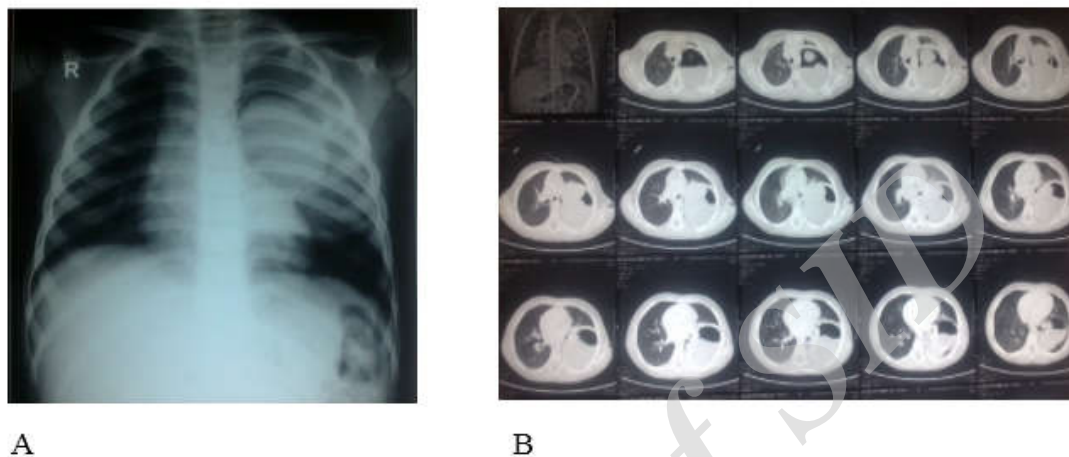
A: Chest X- ray, B: Chest CT scan
